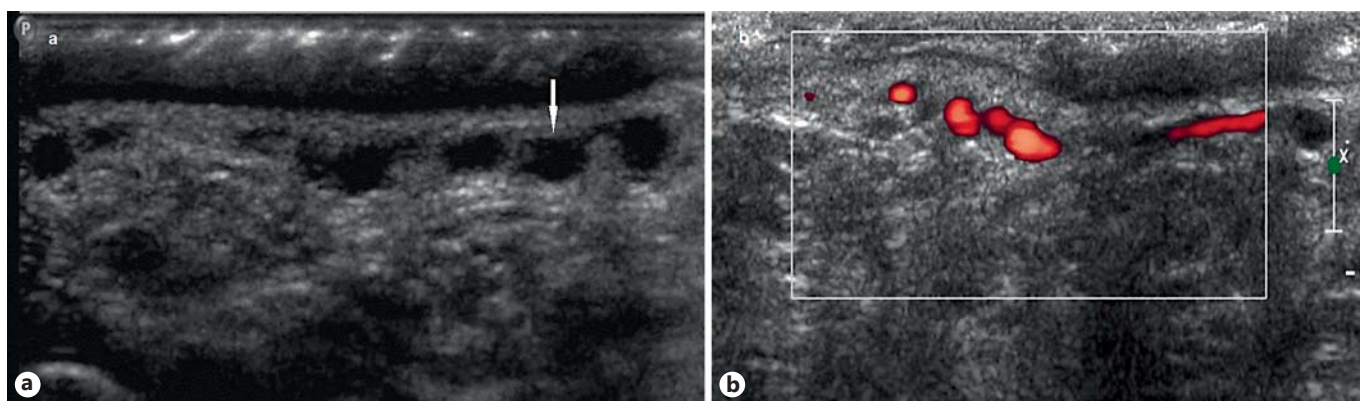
Ultrasound and color (power) Doppler scans performed over the calluses at the distal plantar foot in a PC patient. Engorged varicose veins are demonstrated in the dermis at the distal plantar foot, on gray scale (arrow) (a) and on power Doppler (color box) (b).
